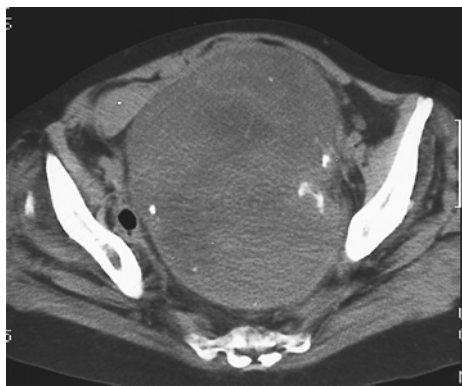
CT scan shows the maximum transverse and antero-posterior dimension. (4.24.84).
